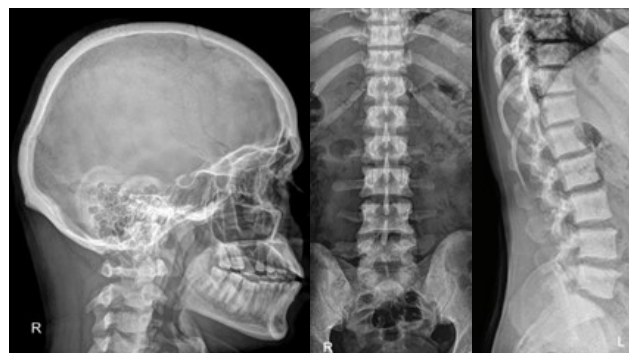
X-rays showing diffuse sclerosis of bones.
